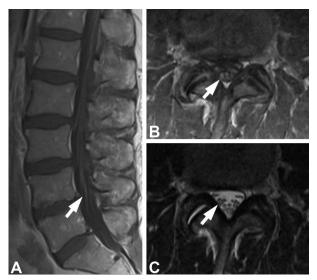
A 63-year-old man with a history of COVID-19 infection 2 weeks before presented with difficulty urinating. Physical examination reveals diminished vibration and pinprick sensation. A lumbar spine MRI demonstrates thickening and enhancement of the cauda equina nerve roots (*arrows*) on (A) T1 sagittal and (B) axial sequences. C. A T2 axial sequence demonstrates nerve root thickening (*arrow*).
